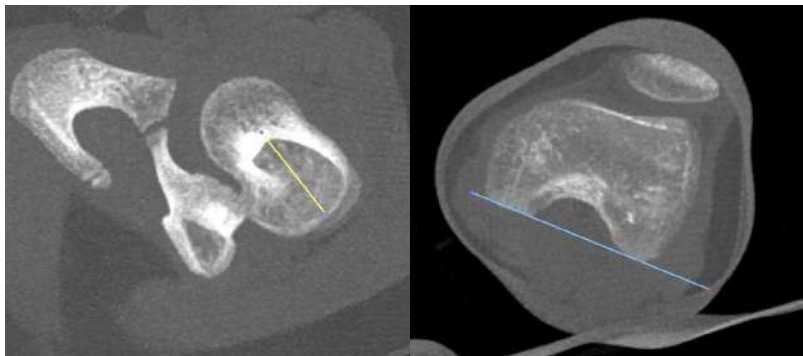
Sample image of the measured CT scan. The measurement method is as described by Hernandez et al¹². On the left is the angle taken from the femur neck. On the right is the angle taken from the posterior border of the medial and lateral condyle. The measured angle is the difference between the two lines.
